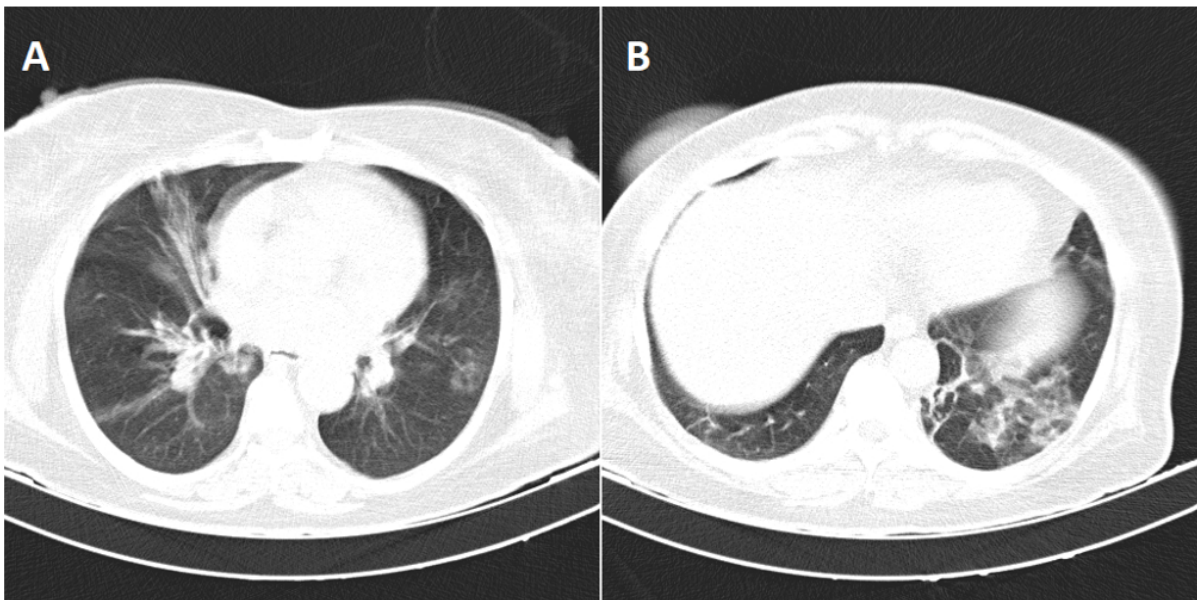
Thoracic computed tomography of lung window shows multifocal and diffuse ground glass patches over both lung fields resembling COVID-19 infection (A). The reticular and “tree in buds” sign and mosaic pattern in the left lower lobe of lungs suggests superinfection (B)
